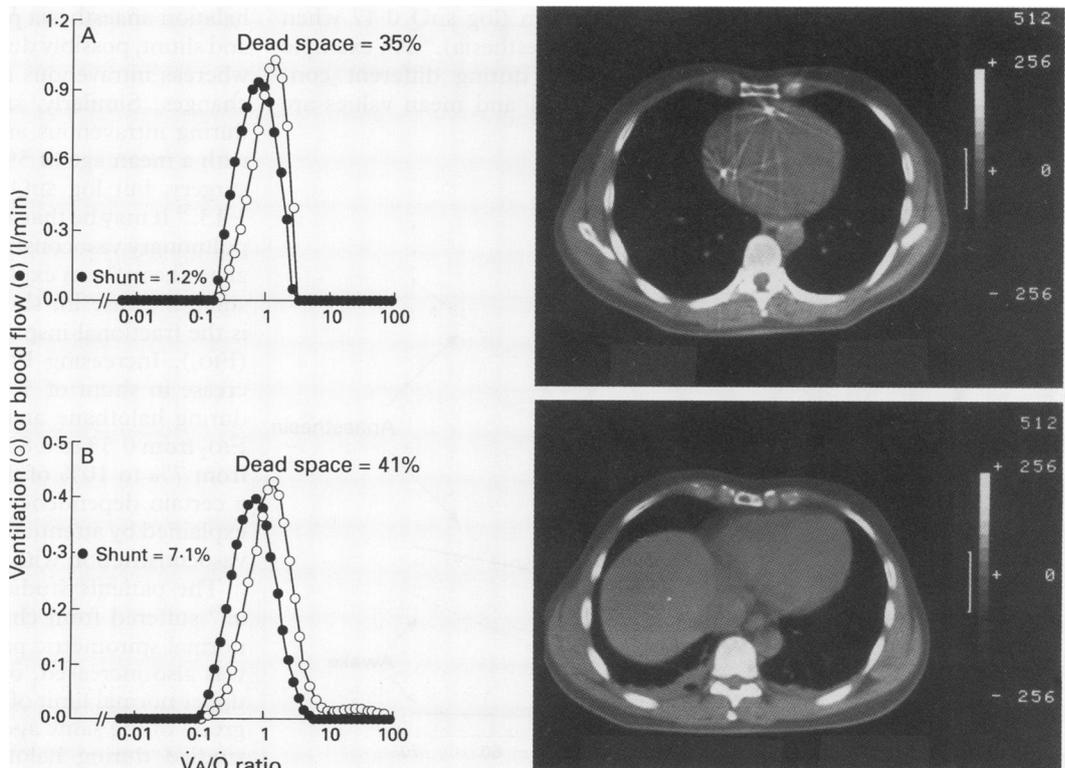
Transverse computed tomographic (CT) scans of the chest and \dot{V}_A/\dot{Q} distributions in a patient who was to undergo cholecystectomy (A) when awake, and (B) during anaesthesia and paralysis prior to surgery. When awake there were no densities in dependent lung regions on the CT scan and the \dot{V}_A/\dot{Q} distribution was normal. During inhalational (enflurane) anaesthesia and paralysis dense regions are seen in dependent lung regions on the CT scan. Shunt increased with widening of the \dot{V}_A/\dot{Q} distribution (increased $\log SDQ$). From Gunnarsson et al.⁵⁰
